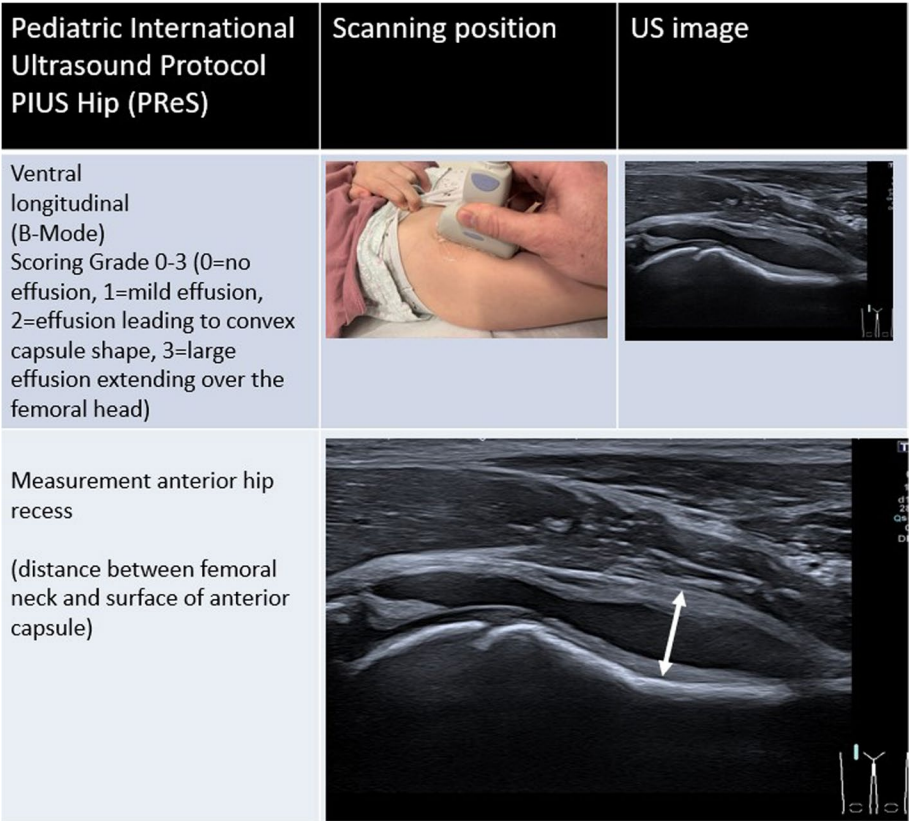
Overview of the PIUS-Hip Ultrasound Protocol for Synovitis. The anterior longitudinal view, with ultrasound probe position, corresponding example of B-Mode image is shown, along with the pediatric OMERACT grading criteria for B-Mode findings. The measurement of the anterior hip recess is also shown, also performed in the anterior longitudinal view, which forms the second necessary image to fulfil the PIUS-protocol
